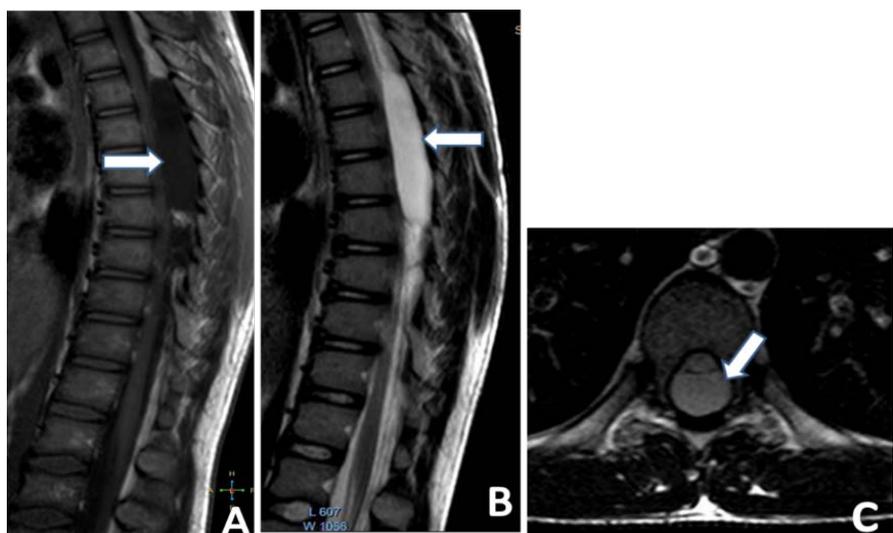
Sagittal MRI of thoracic medullary T1-weighted (A) T2-weighted (B) and axial (C) showing the arachnoid Cyst (White arrow).
